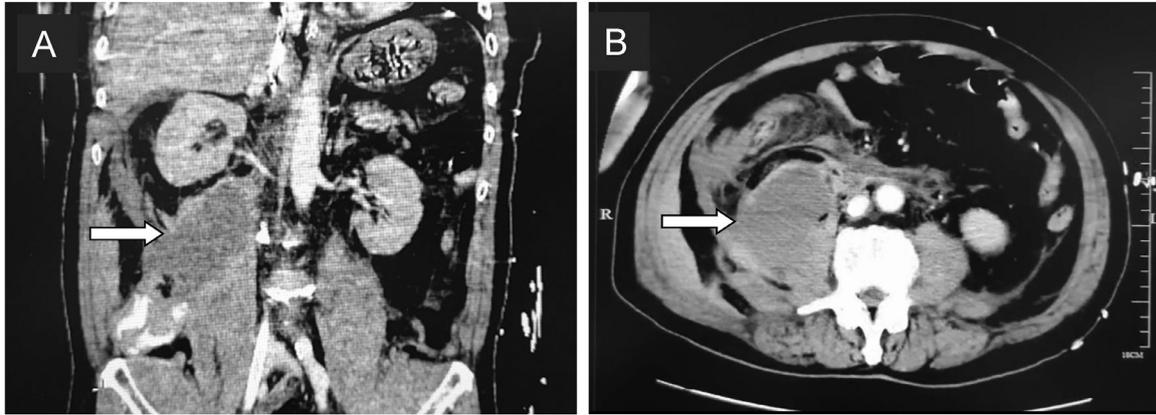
Computed tomography showing a giant cystic density shadow in the right retroperitoneal renal space, with leakage of contrast medium after enhancement.
